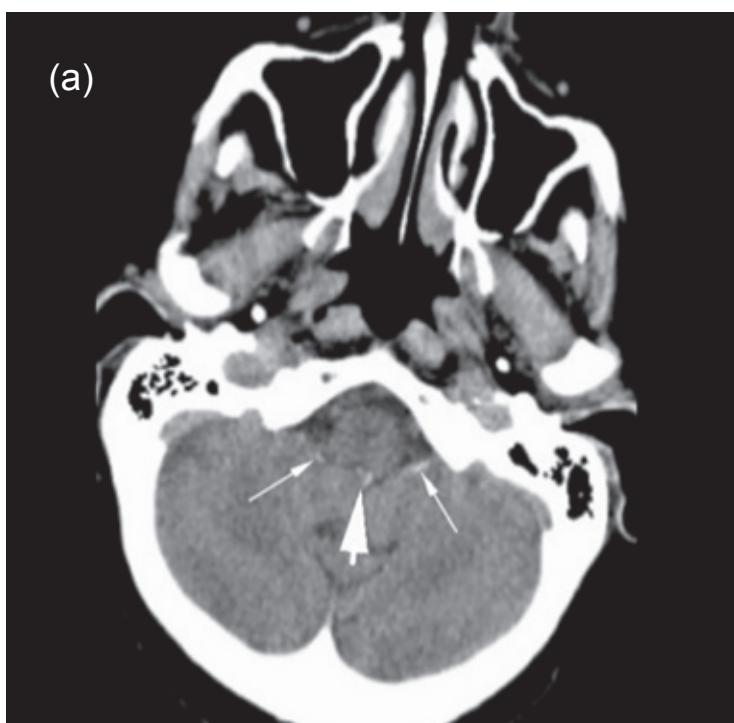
Unenhanced CT brain axial image showing hyper densities within the fourth ventricle (large arrow) and in the foramen of Luschka on either side (small arrows).
